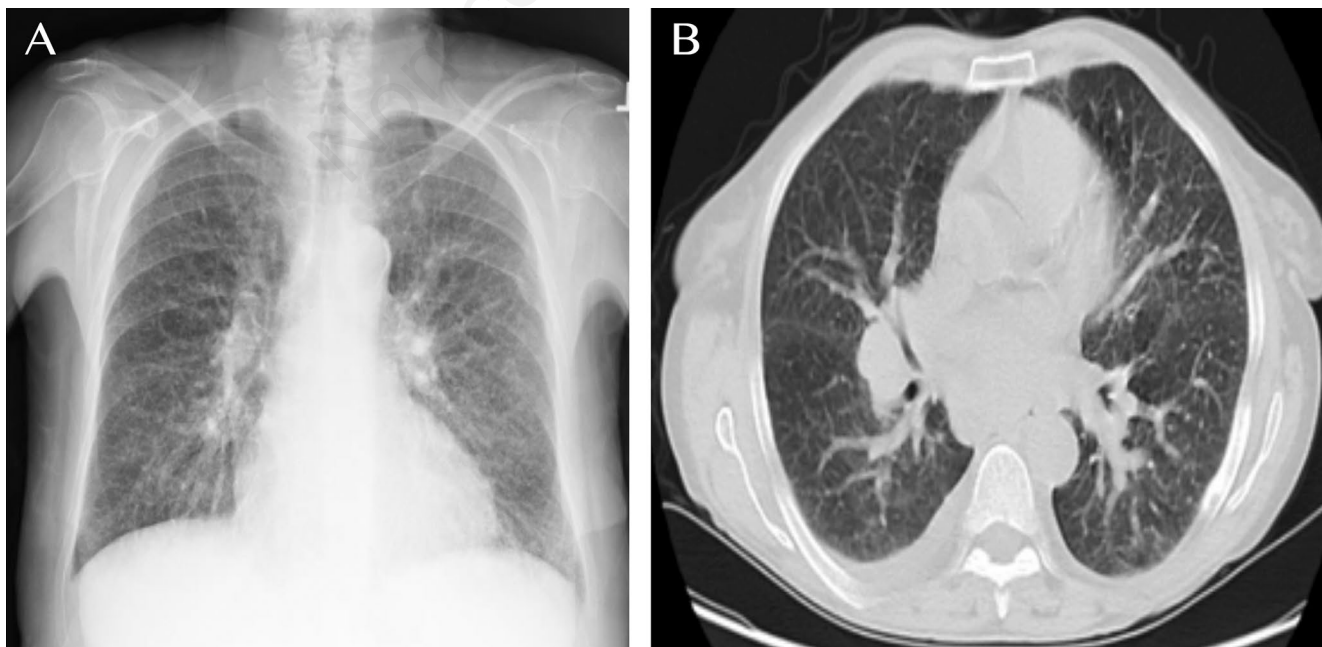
Chest X-ray (a) and thorax CT (b) revealing diffuse micronodules in both lungs.
